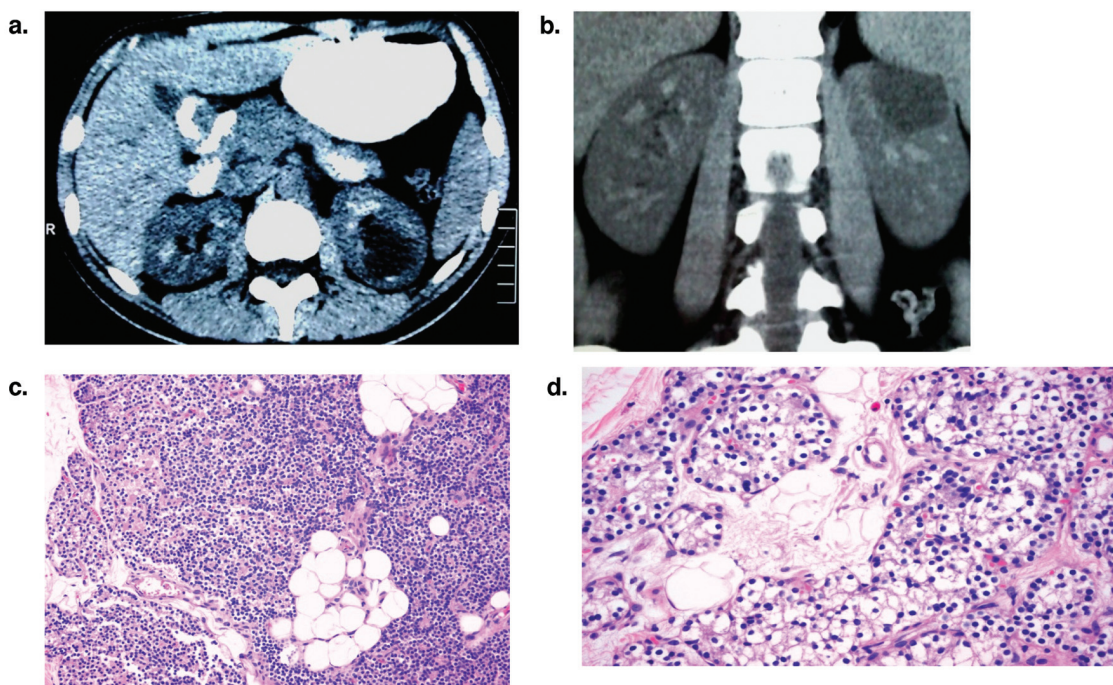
a and b: Axial (a) and coronal (b) abdominal CT images compatible with nephrocalcinosis. c: Hyperplastic parathyroid gland composed predominately by chief cells and a small component of oxyphilic cells (H-E x 100). d: Area of another hyperplastic parathyroid gland composed predominately by clear cells (H-E x 200).
